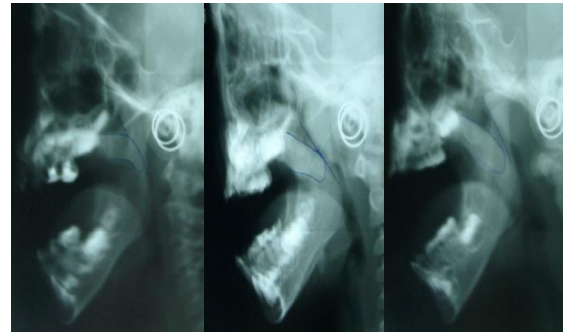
The results of cephalometric radiograph examination when pronouncing the vowel 'a': (1) had contact at 3 points; (2) had contact at 1 point; (3) had no contact
